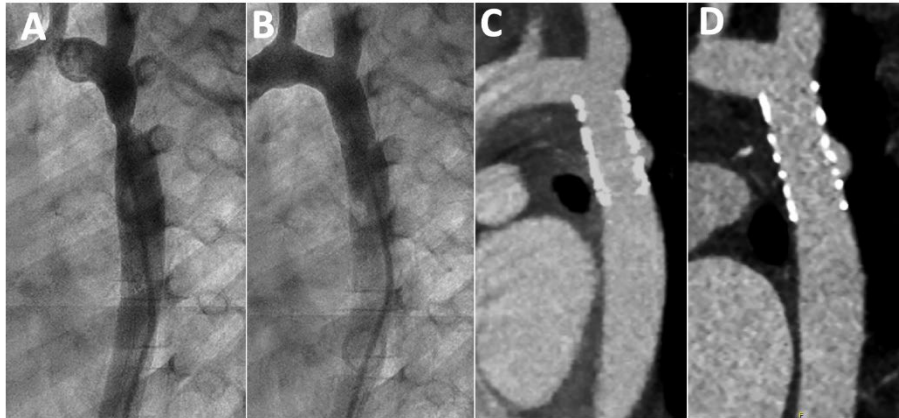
of the supplementary data. Serial CT follow-up of a patient with a small aneurysm. A, baseline angiography; B, immediate result after stent implantation; C, CT at 4 years; D, CT at 6 years of stent implantation. CT, computed tomography.
